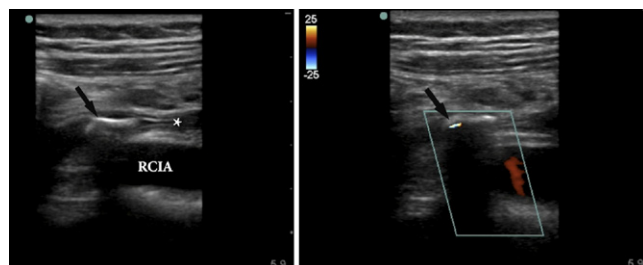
The right ureteral stone (black arrow) is now shown with a linear transducer in B-mode (left). The ureter appears 3 layered (*) and is found directly over the RCIA. The color Doppler image (right) shows a classic “twinkling” deep to the calculus (black arrow).
